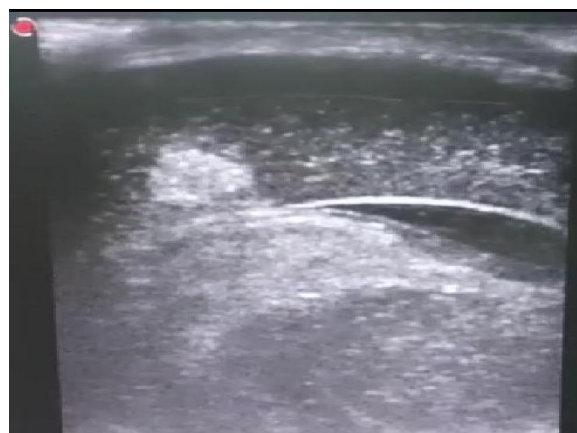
Sonography through mastoid approach shows hyperechoic foci involving parenchyma suggestive of intraparenchymal haemorrhage.
